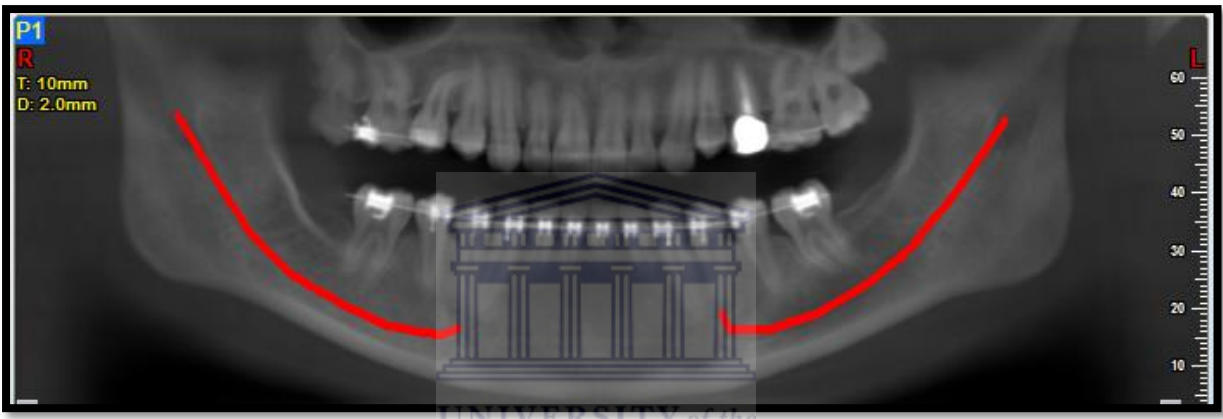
Orthopantomogram 10 mm thick with identification of inferior alveolar nerve
